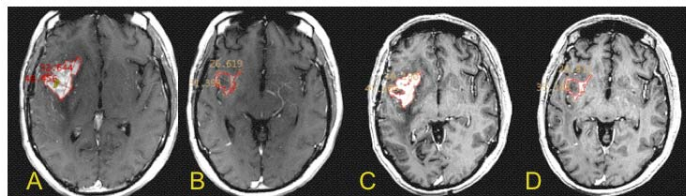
Comparison of linear and volumetric methods. Post-contrast thick(A-B) and high resolution (C-D) T1WI MRI of 60 years old male with recurrent GBM, prior to initiation of anti-angiogenic therapy(A, C) and 96 days later(B, D). Bidimensional measurements are shown per definition. The enhancing tumor is also outlined in red per typical volumetric analysis. If diameter measurements are used to estimate cross sectional area, the lesion has shrunk to 60% of its original size on At and 65% on Ah respectively, and both of them would be classified as stable disease. Using volume measurements(including all enhancing tissue, not only on the image shown but the entire lesion) the lesion has decreased to 24% of its original size on Vt and 31% on Vh respectively, and both of them would be classified as partial response. At: diameter-based area on post-contrast thick T1WI; Vt: volume on post-contrast thick T1WI; Ah: diameter-based area on post-contrast high resolution T1WI; Vh: volume on post-contrast high resolution T1WI.
